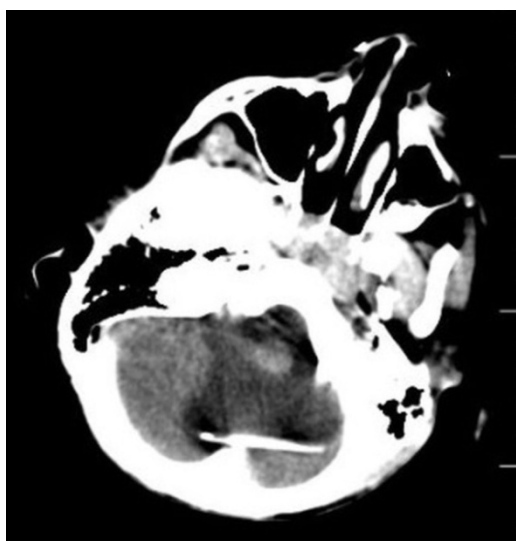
On non-contrast axial brain CT scan, free floating ventricular catheter was seen in the 4th ventricle.
